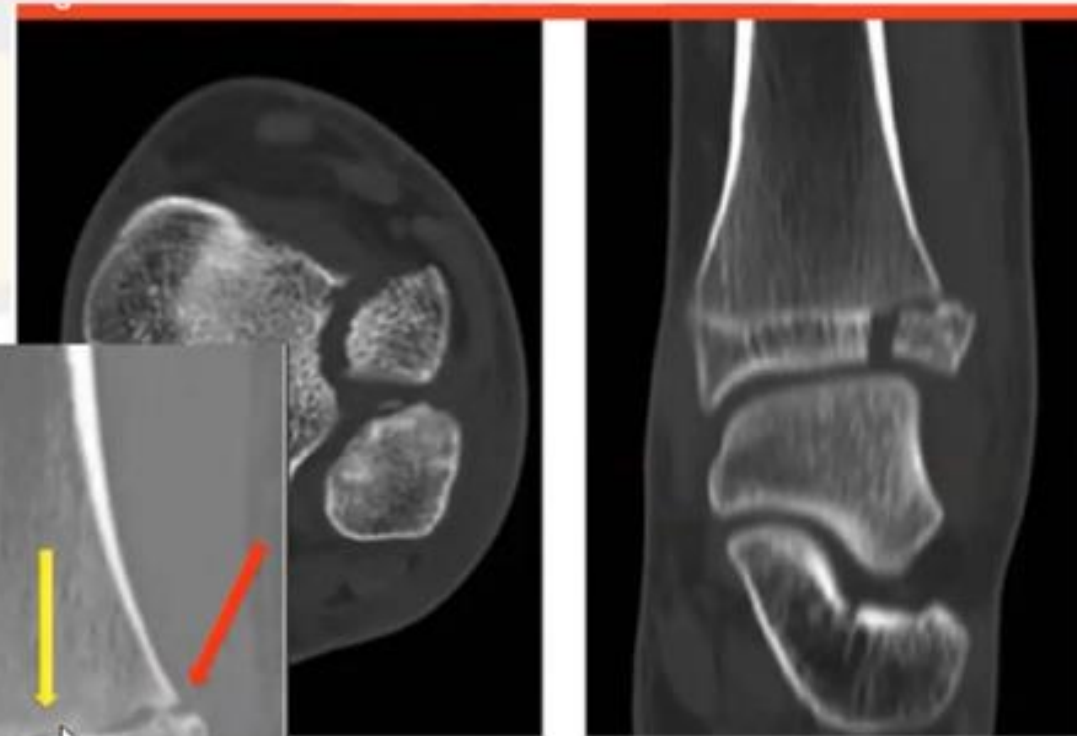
Coronal (B) CT scans of a Tillaux fracture. Note the Salter-Harris type II fracture with displacement.
